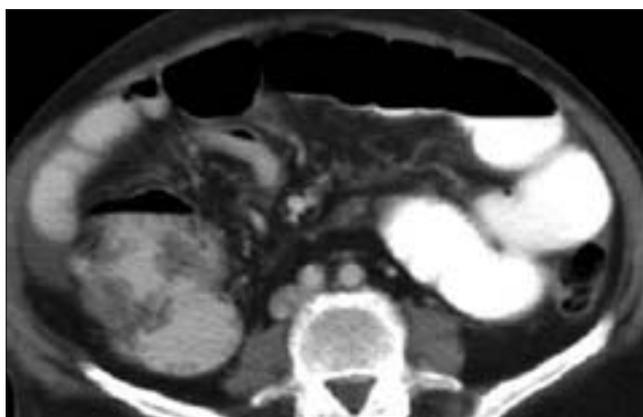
Axial CT image shows asymmetrical mural thickening of the cecum in a case of cecal cancer, resembling an inflammatory mass.
